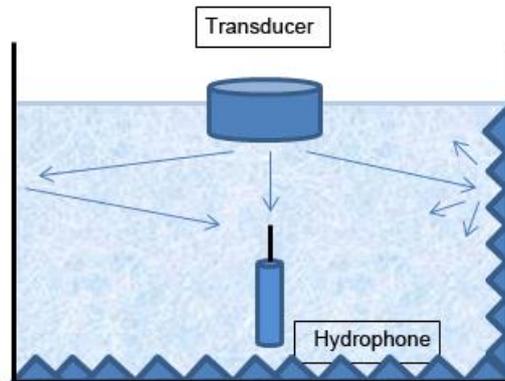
Hydrophone-transducer set-up. On the left side of the water tank there are strong reflections from the tank wall while on the right wall, which is lined with uneven ultrasound absorbing material, the ultrasound reflections are weaker due to both scattering and absorption.
